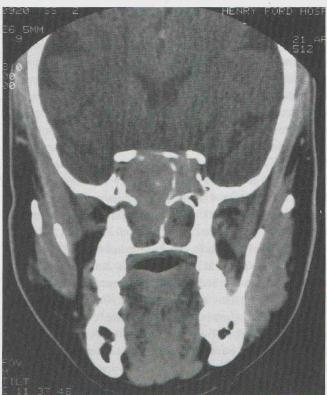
CT scans of paranasal sinuses showing expansile sphenoid/ ethmoid mass extending intracranially into the cavernous sinus (a: axial; b: coronal).
